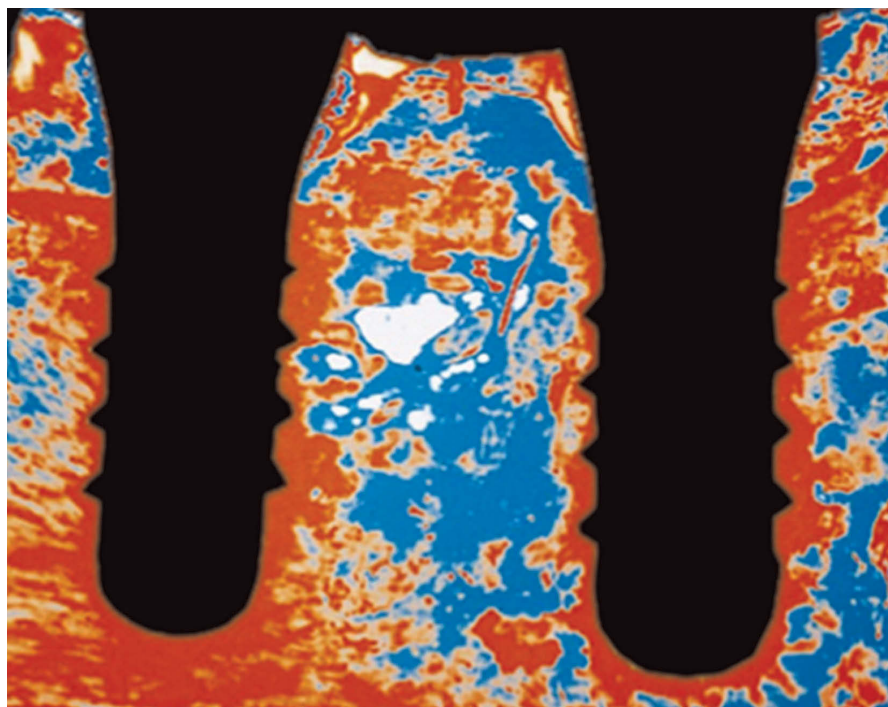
In this image from Akin-Nergiz et al¹ study, radiographic bone densitometry of areas where two osseointegrated implants were subjected to orthodontic load. It is highlighted the increased bone density (in red) in the areas of compression and tension sides, when compared to the original alveolar cancellous bone, in blue.
